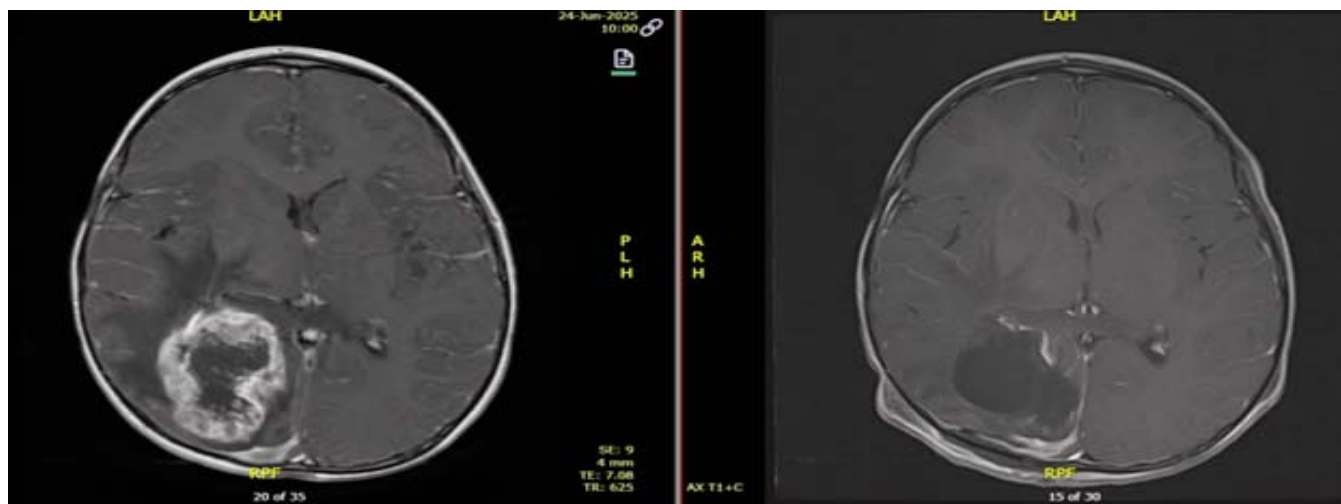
Preoperative and postoperative MRI brain T1WI with contrast of a patient with DNET, who underwent complete excision of the tumour.
